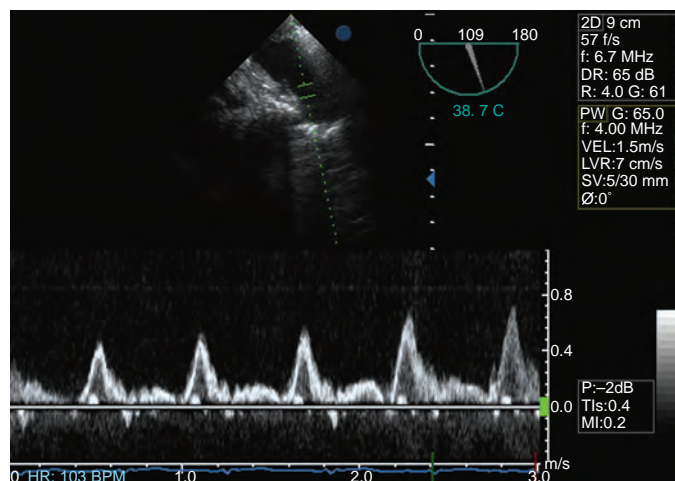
Pulsed-wave Doppler interrogation of the left superior pulmonary vein after lung transplantation.
